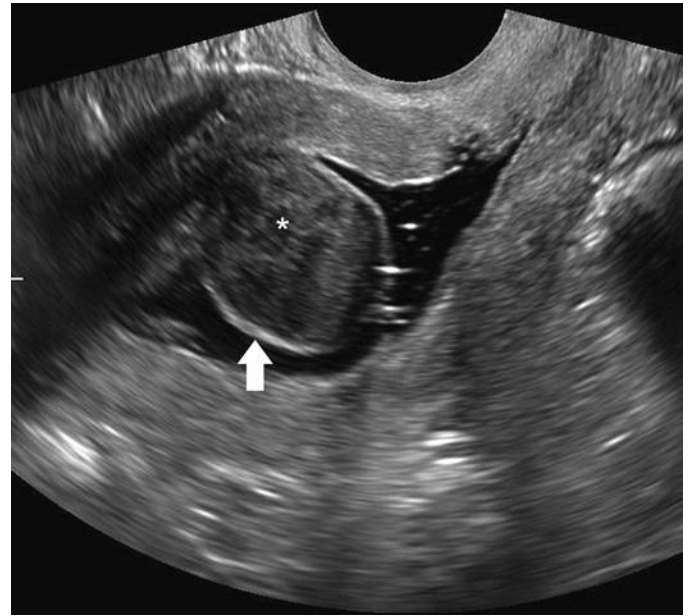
Submucosal, predominantly intracavitary leiomyoma (asterisk) well demonstrated by saline infusion sonohysterography on this sagittal transvaginal ultrasound image. Note the thin overlying rim of echogenic endometrium (arrow) covering the myoma.
